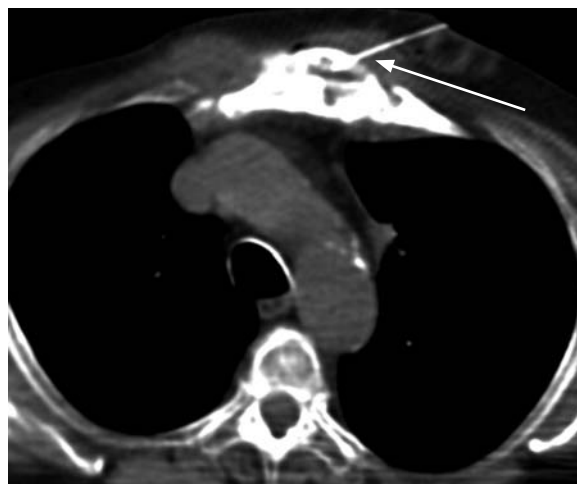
CT-guided coaxial FNA of a breast cancer metastasis to the sternum (arrow)
